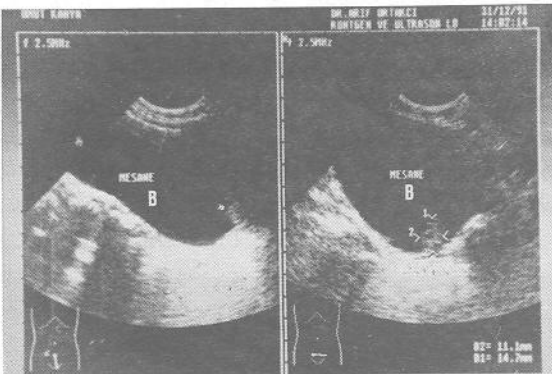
Bladder (B) sonogram of the second case, showing the polyp (arrows) in the lumen
